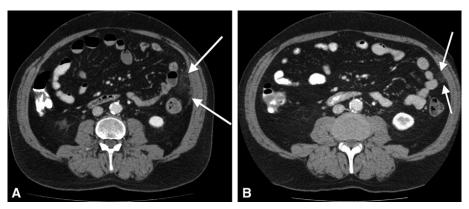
(A) Axial contrast-enhanced computed tomography (CT) image, depicting fatty mass (arrows) at the left mid abdomen, representing omental infarction. (B) Follow-up CT performed 1 month later, showing marked improvement of infarction (arrows).
